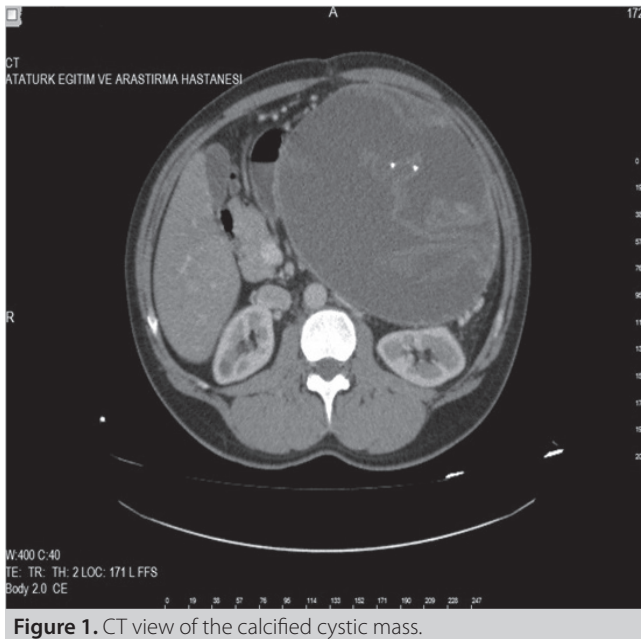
CT view of the calcified cystic mass.
